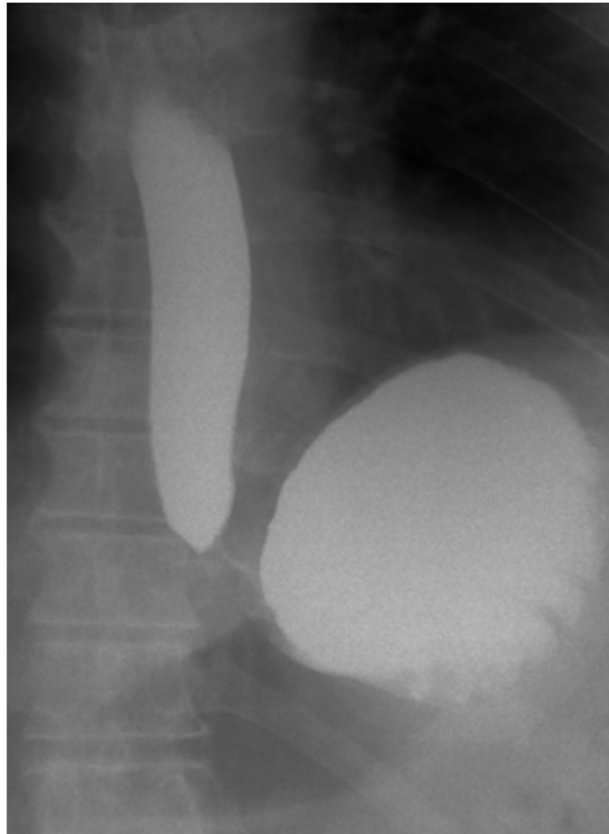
X-ray of the esophagus and EGJ at high pressure in the stomach. There is no peristalsis in the esophagus. The width of the esophagus is 2.7 cm, and the length of the LES is 1.9 cm. XRI is 1.4. Conclusion: Mild GERD.
